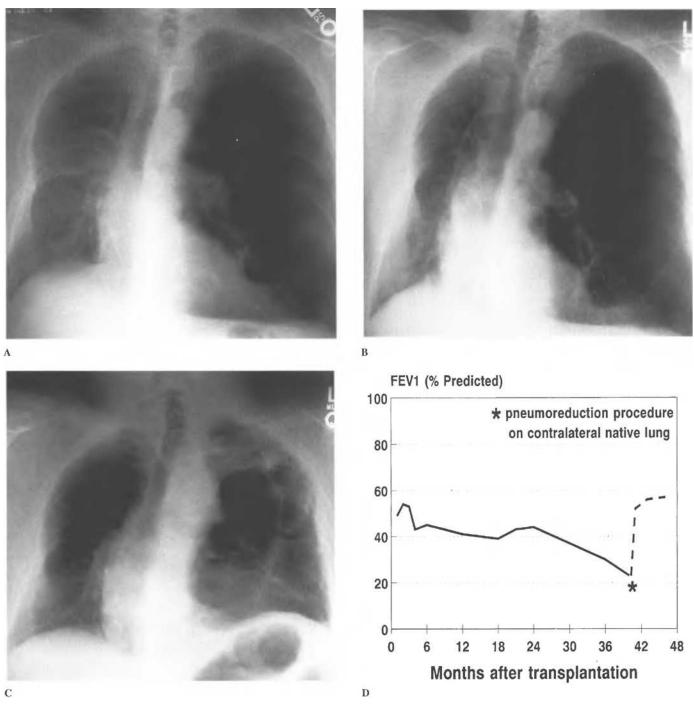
Chest radiographs and pulmonary function data in a single-lung recipient with emphysema. A: X-ray 1 month after transplantation. B: X-ray 3 years after transplantation showing compression of transplant lung. C: X-ray 3 months after unilateral pneumoreduction. D: Change in FEV<sub>1</sub> before and after pneumo-reduction
